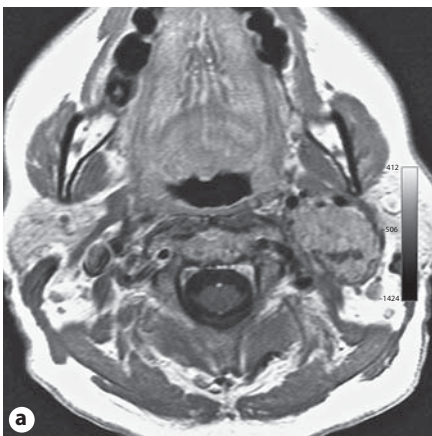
Case No. 13. a Axial T₁-weighted MR image showing a left VP; the ICA is displaced anteromedially; the external carotid artery is anterolaterally displaced; the internal jugular vein is compressed by the mass and not visible. b Coronal T₂-weighted MR image showing the craniocaudal extension of the left VP (*) and its relationship with the ICA (arrowheads); note the presence of a kink (big arrowhead) in the ICA immediately beyond the upper pole of the VP. c Insertion of an Xpert Stent into the proximal cervical segment of the left ICA; the presence of a kink (arrow) is an obstacle to the insertion of the stent in the more distal portion of the cervical ICA. d The stent is deployed in the proximal cervical segment, with the guide wire still in place.
